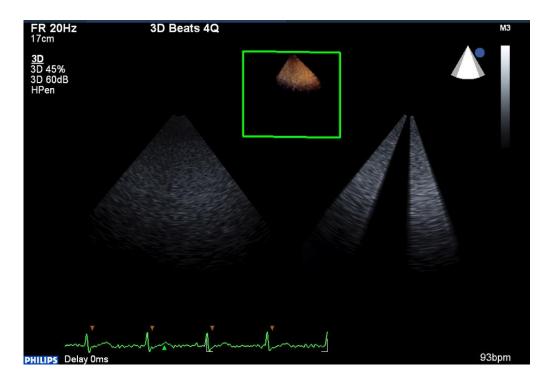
Image demonstrating the "stitching" of several ultrasound subvolumes, which allows a higher temporal resolution without loss of spatial resolution. Two of the four subvolumes being stitched together are evident on the right hand view.
